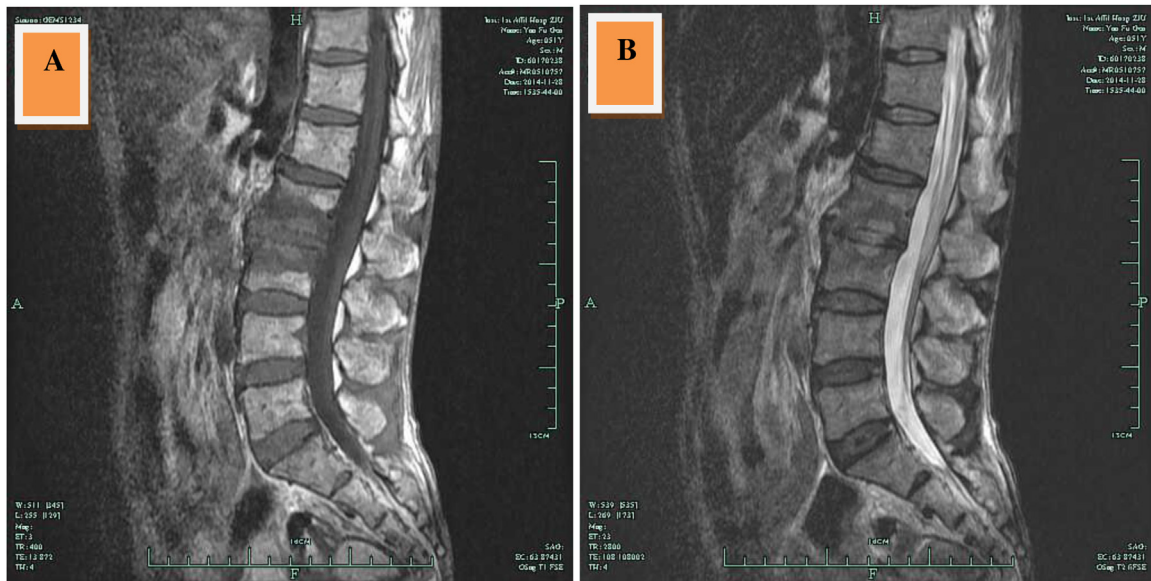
Magnetic resonance image of the dorsal spine showing an L2–L3 spondylodiscitis: T1-sagittal MRI image of the lumbar spine reveals hypointense signal within the L2–3 disc and associated destruction of vertebral bodies and compromise of the spinal cord at this level (A). T2 sagittal MRI reveals hyperintense marrow signal (B).
